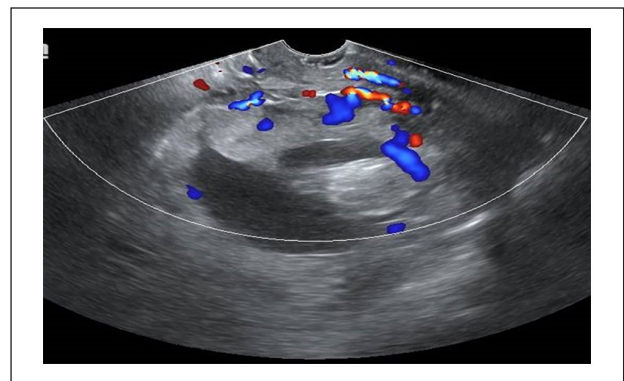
Colour Doppler ultrasound of the placental site on transvaginal US showing increased vascularity at the placental bed.
